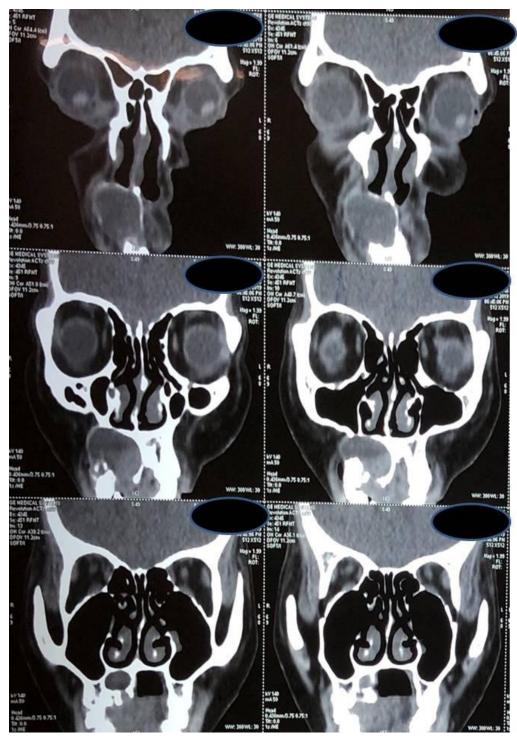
Preoperative computed tomography of the paranasal sinuses
